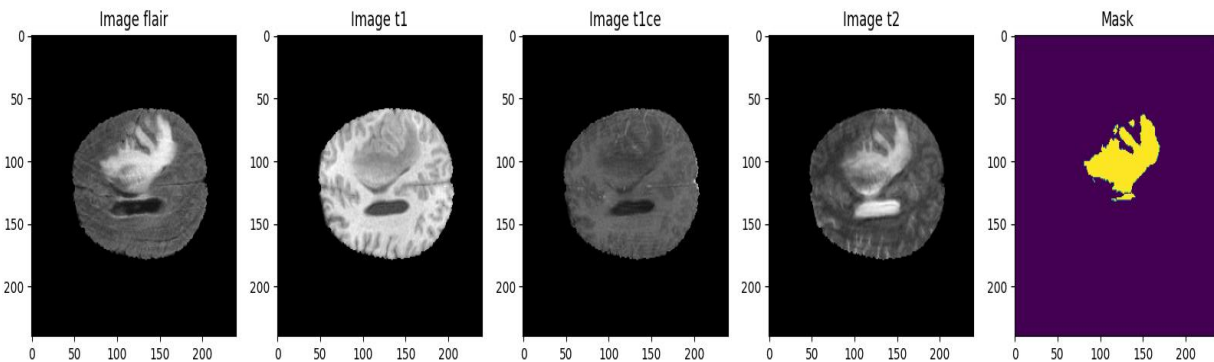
Multimodal brain MRI visualization with tumor segmentation.
